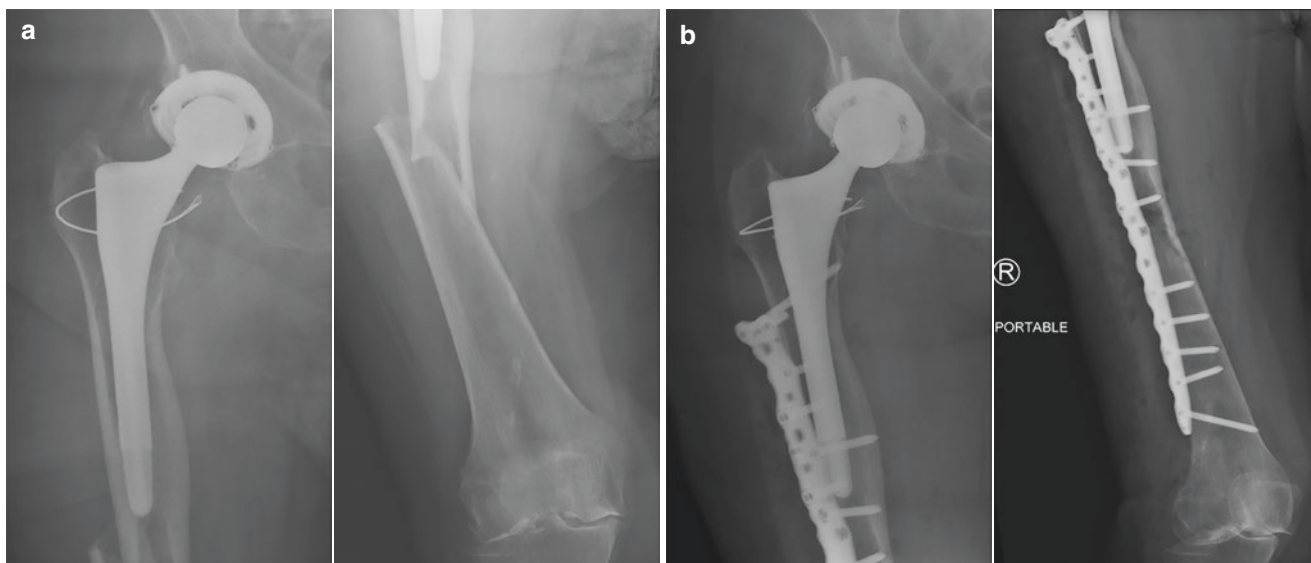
(a, b) Preoperative and postoperative radiographs, respectively, of an 86-year-old female with multiple myeloma who sustained a pathologic periprosthetic femur fracture of the Vancouver C variety, for which she underwent open reduction with internal fixation
